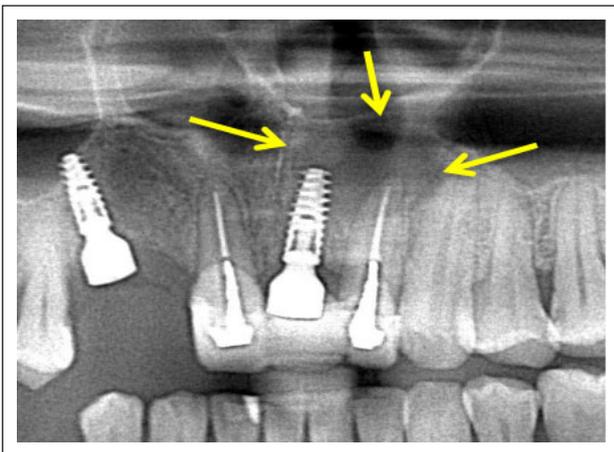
Dental implant located at premaxilla region with a large periapical lesion (arrows), which was most likely started by the adjacent devitalised tooth.
